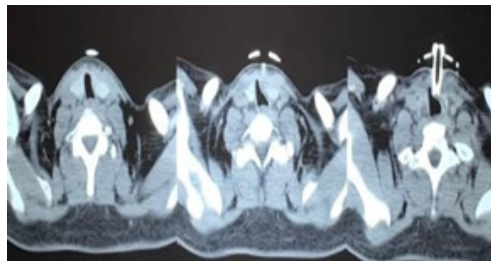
Contrast enhanced Computed tomography of neck showing supra stomal airway narrowing
